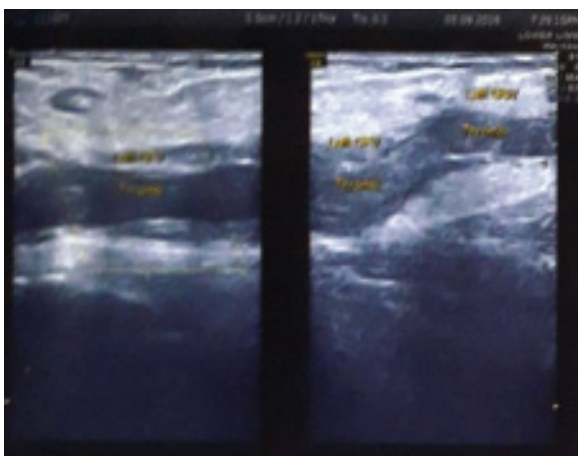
Doppler study of the left lower limb showed occlusive thrombus
